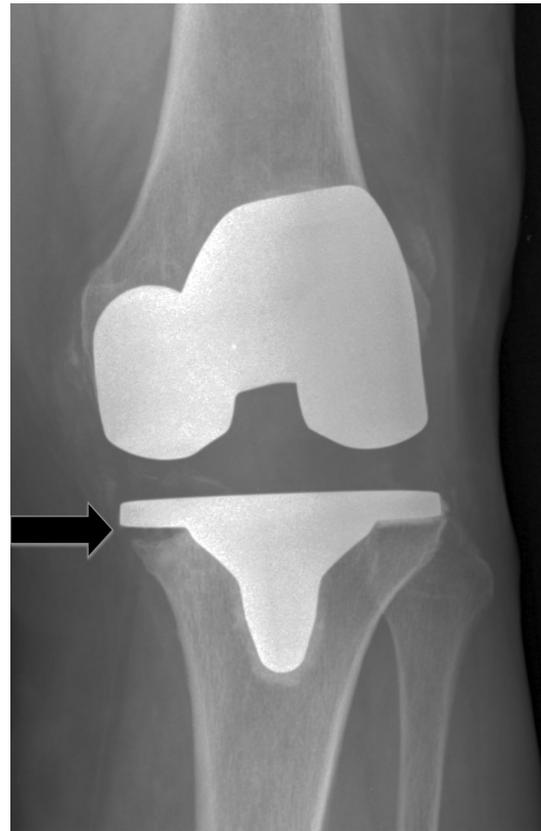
Anteroposterior radiograph at 11.4 years post-operatively, showing a radiolucency in Zone 1 of the tibial implant >2 mm
